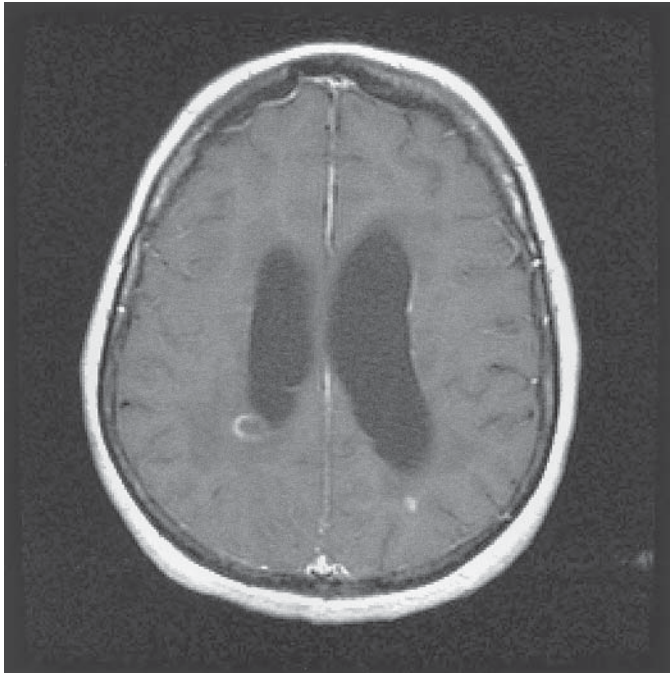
T1 weighted, postgadolinium MRI scan shows two enhancing lesions. Note the incomplete ring enhancement of the right periventricular lesion. This patient had demyelination and not cancer.
